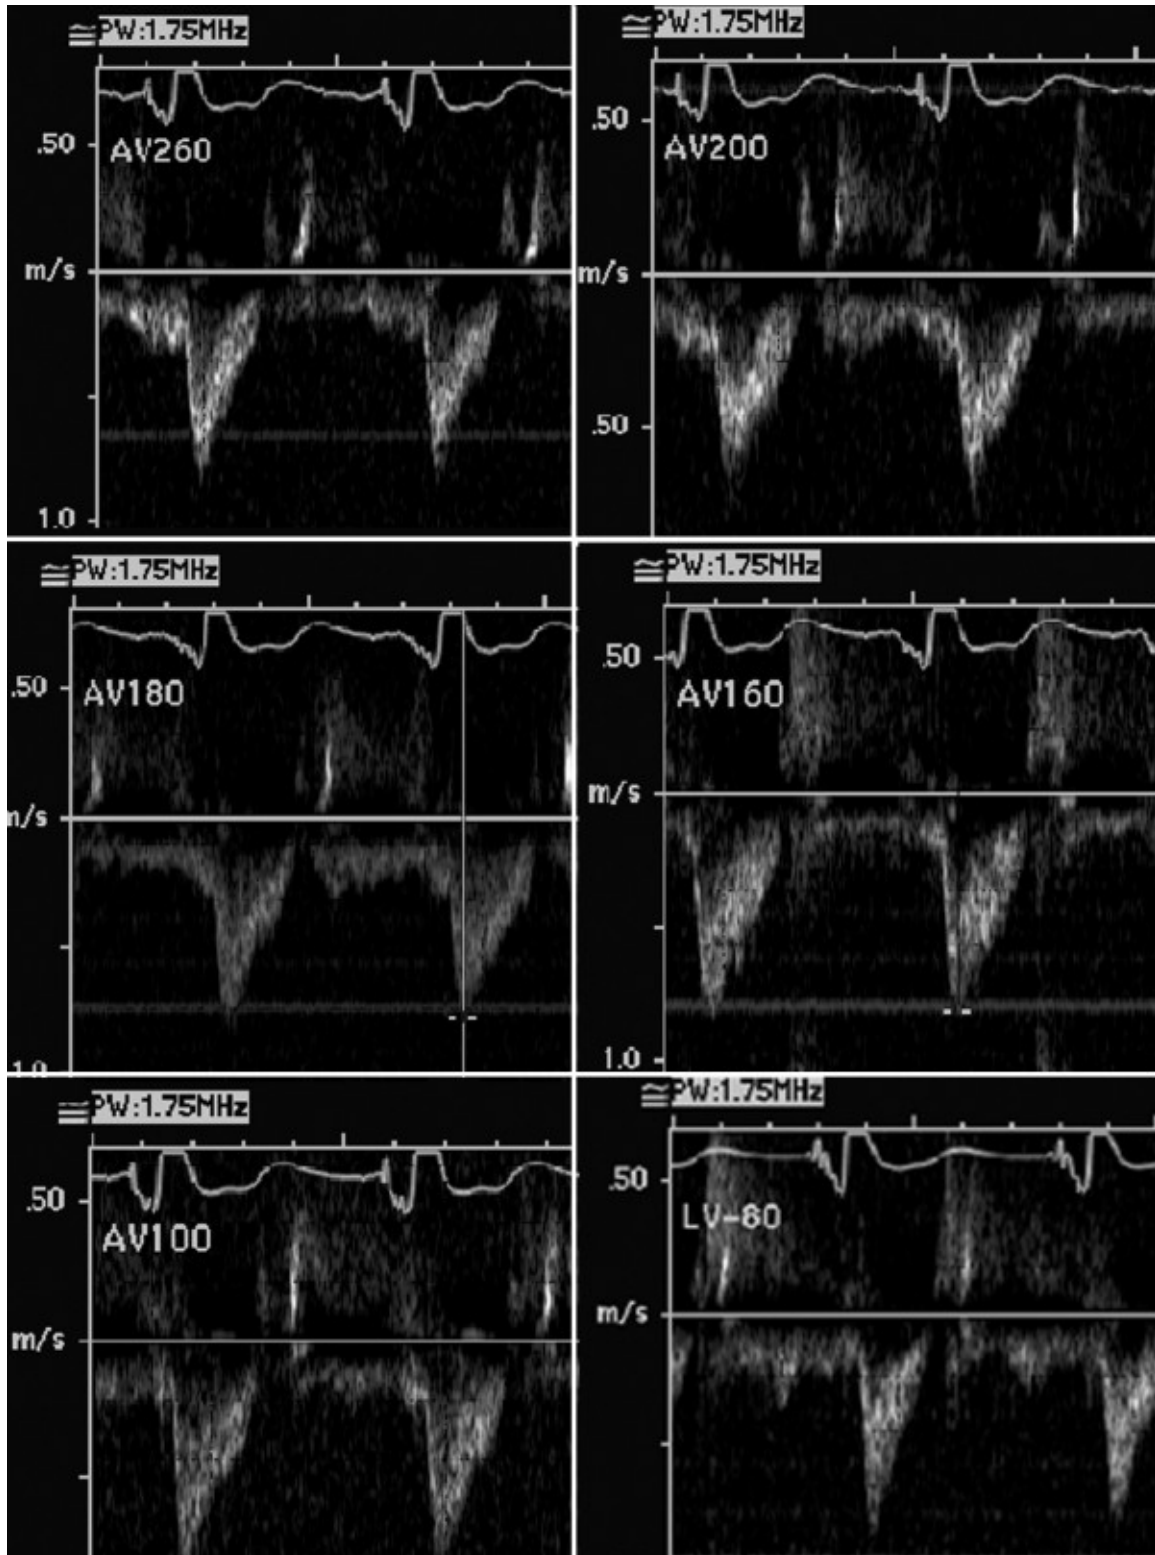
a-f. Left ventricular outflow Doppler profiles with changing A-V intervals (in milliseconds). See text for details.
